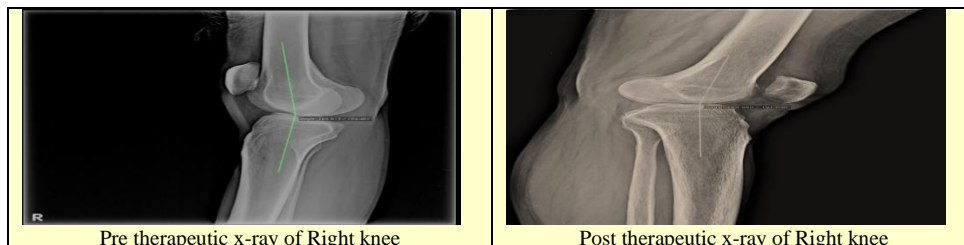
Shows Patient 3 Pre vs. Post Therapeutic X-ray of Right Knee
